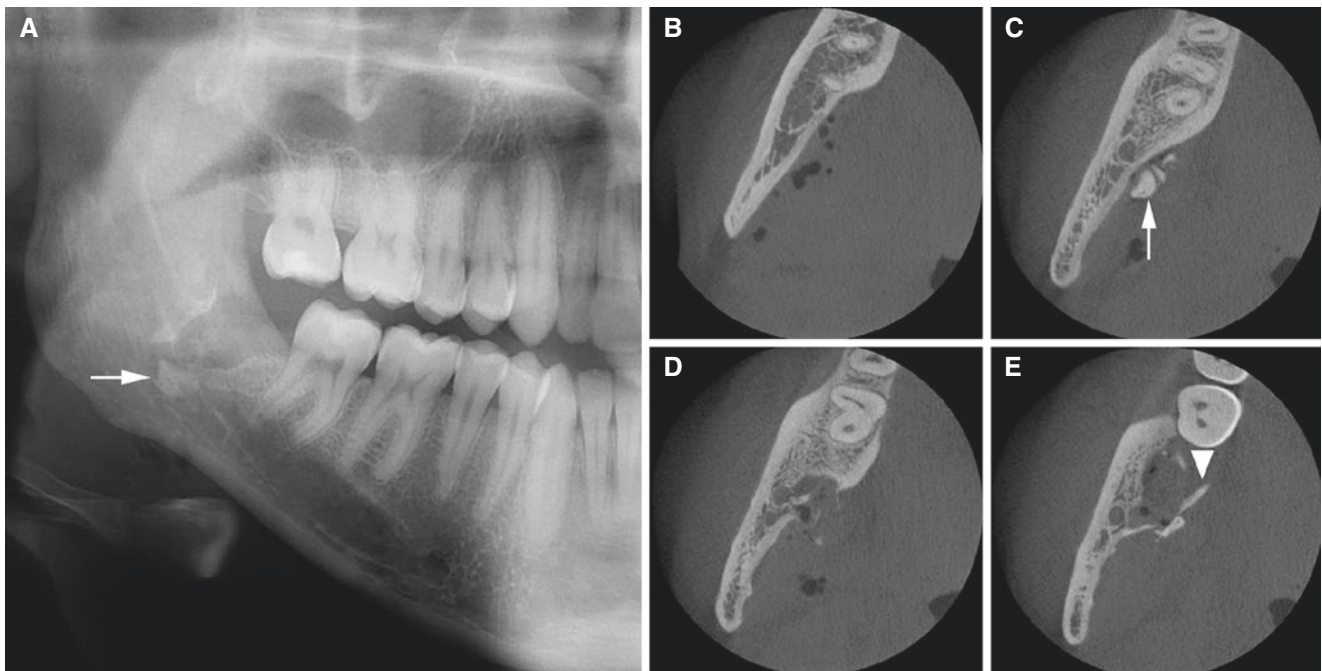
Postoperative condition after removal of wisdom tooth, mandible, with question about remaining root; 22-year-old female with immediate postoperative imaging. (A) Panoramic view suggests possibility of remaining root (*arrow*). (B, C, D, E) Axial CBCT images show
